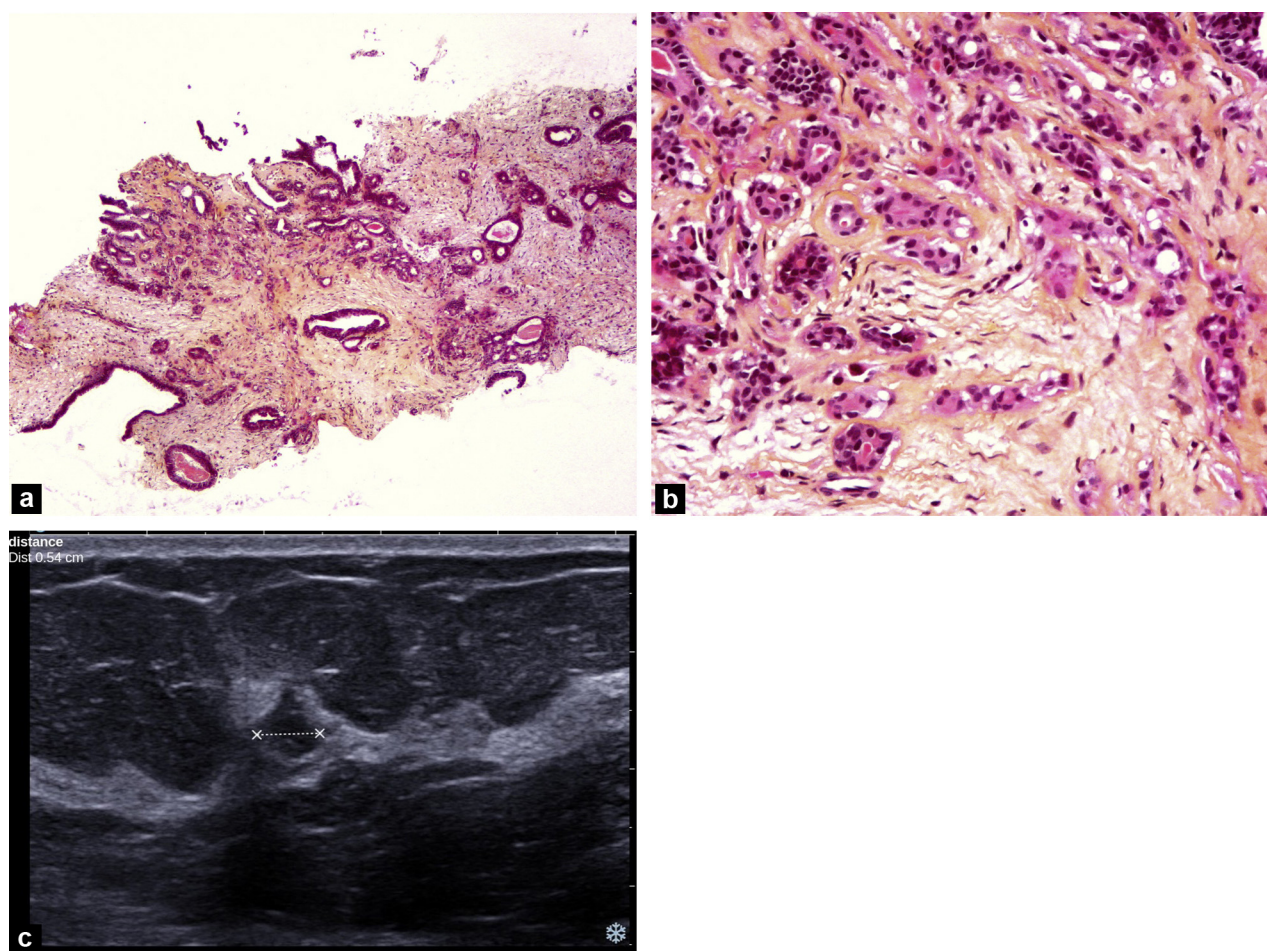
Infiltrating ductal carcinoma. a: core biopsy under sonography: destruction of the normal epithelial structures by a malignant infiltrating proliferation; b: HES $\times 64$. Formation of tubes and framework; c: sonogram: irregular mass of 5 mm.
